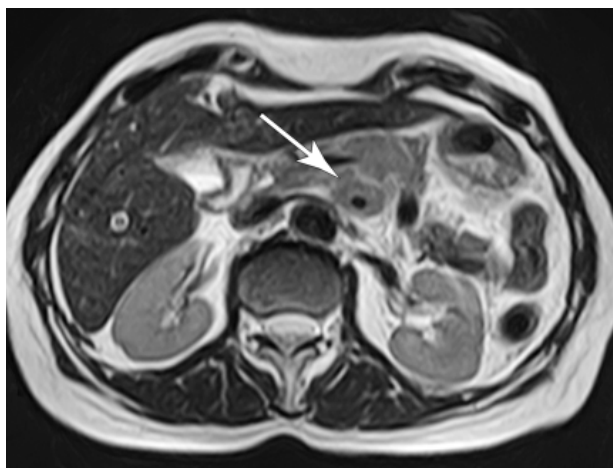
MRI (20/01/18). MRI findings: The mass in the body of the pancreas that covers the celiac trunk and the common hepatic artery, liver cysts. After administration of a contrast, an increase of the MR signal in the arterial, portal, and venous phases was not visualized
